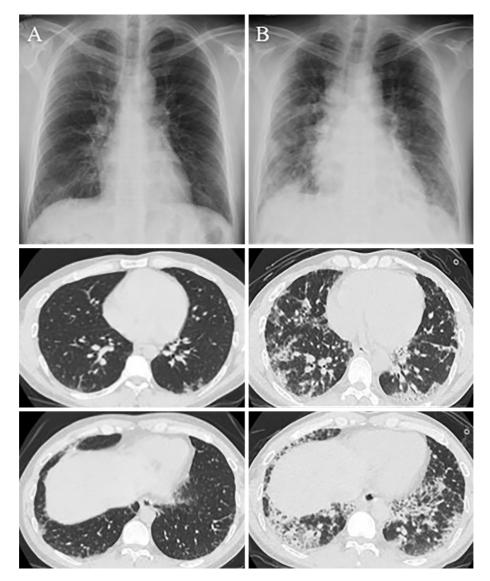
High-resolution computed tomography (HRCT) images of the patient. At a routine medical checkup, reticular abnormalities and ground-glass attenuations were predominantly seen in the subpleural area (A). HRCT images at the onset of acute exacerbation (three years after the routine medical checkup) showed diffuse areas of ground-glass attenuations superimposed on the underlying fibrotic reticular opacities (B).
